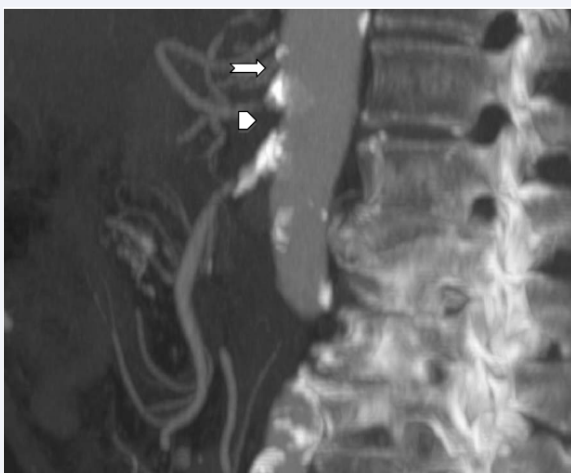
Case 1. Preoperative CTA demonstrates severely calcified occlusion of CA (arrow) and SMA (arrow head) – Sagittal plane.
